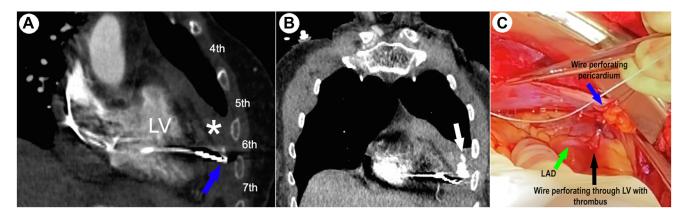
A: Coronal chest computed tomography (CT) on postimplant day 9 shows pacing lead exiting the left ventricle (LV) terminating in the chest wall in the sixth intercostal space (*blue arrow*) with adjacent hemothorax (*asterisk*). B: Coronal chest CT demonstrates pooling of contrast from the left ventricle within the loculated hemothorax (*white arrow*). C: Intraoperative view of anterior wall of the left ventricle, with pacing lead covered with thrombus (*black arrow*) exiting lateral to the left anterior descending artery (LAD) (*green arrow*) and piercing the pericardium (*blue arrow*).
